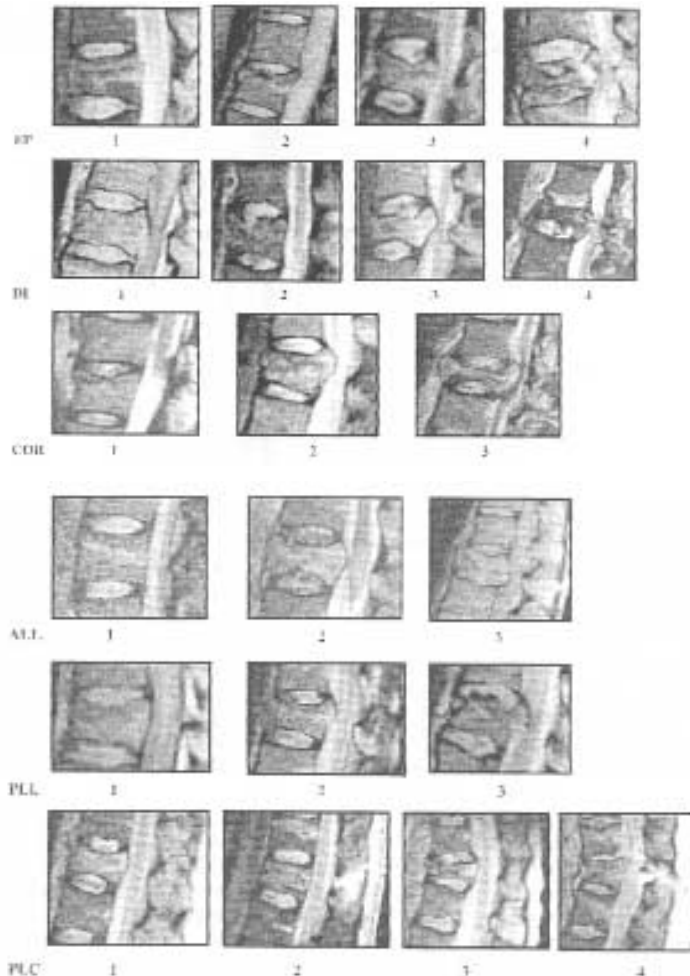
States of the ligamentary structures, endplates, discs and vertebral bodies observed on the MRI's. ALL: Anterior Longitudinal Ligament; PLL: Posterior Longitudinal Ligament; PLC: Posterior Ligamentary Complex. EP: Endplate; DI: Intervertebral Disc; COR: Corpus (Vertebral body). (Oner 1999).
